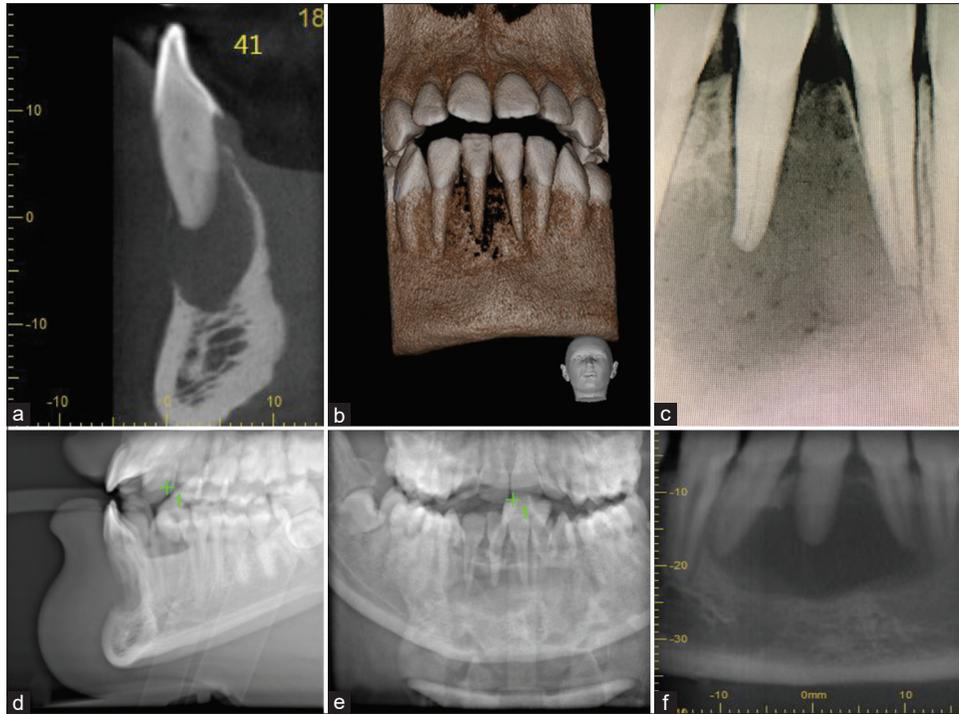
Diagnostic radiographic presentation (a) The cross-sectional CBCT image showed that the root canal was seemingly obliterated, and a large periapical lesion was observed. (b) CBCT 3D reconstruction. (c) The periapical radiograph of the related tooth. (d) Buccal fenestration and, (e), (f) large periapical lesion including teeth 31, 41 and 42.
